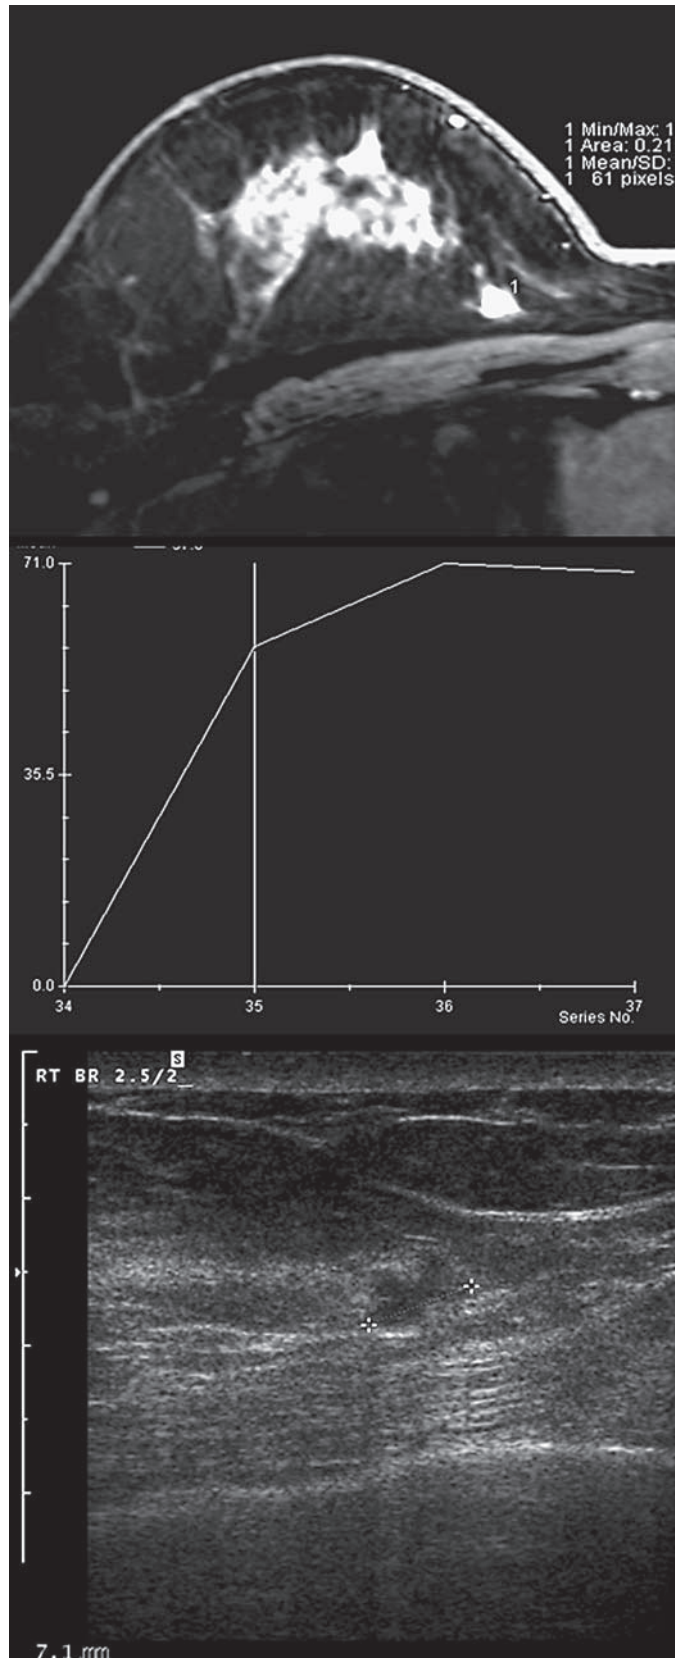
A 44-year-old woman showing a heterogeneously enhanced mass lesion in the left breast by MRI and a hypoechoic lesion with irregular margins by US. US-guided biopsy confirmed an invasive lobular cancer. Follow-up mammography at the breast clinic did not show any abnormalities.
